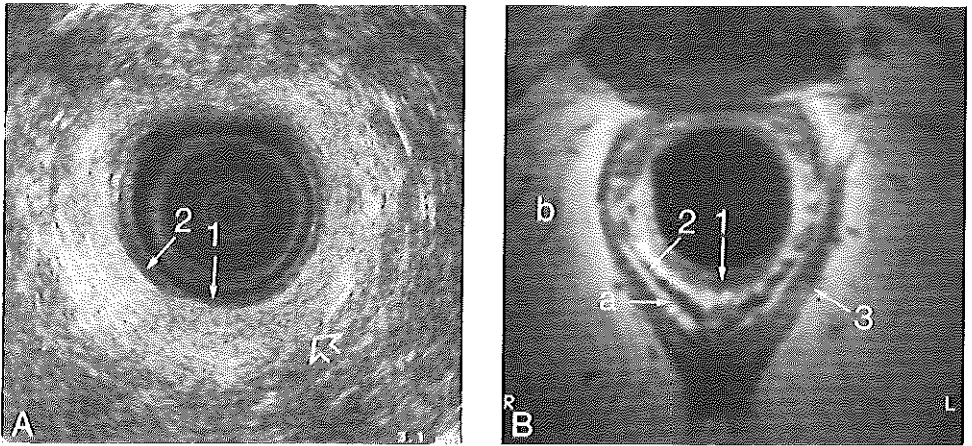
Axial images through the upper part of the external sphincter in a female (level indicated in Fig. 4.6). At this level the internal anal sphincter (1) is well recognizable with both modalities. Just outside the internal sphincter, another thin hypoechoic layer is visible sonographically which corresponds well with the longitudinal layer (2) on the MR image (B). The hyperechoic band containing hypoechoic fibres (open arrow) (A) shows no correlation with the external sphincter (3) apparent with MRI (B). Intersphincteric space (a); Ischioanal fossa (b).
